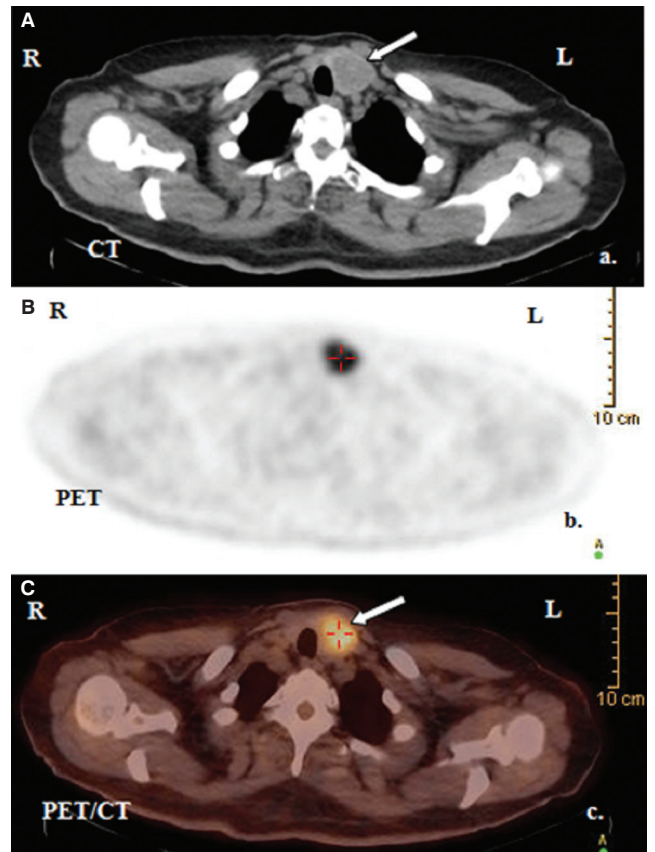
Transaxial scan of the CT, PET and PET/CT.
